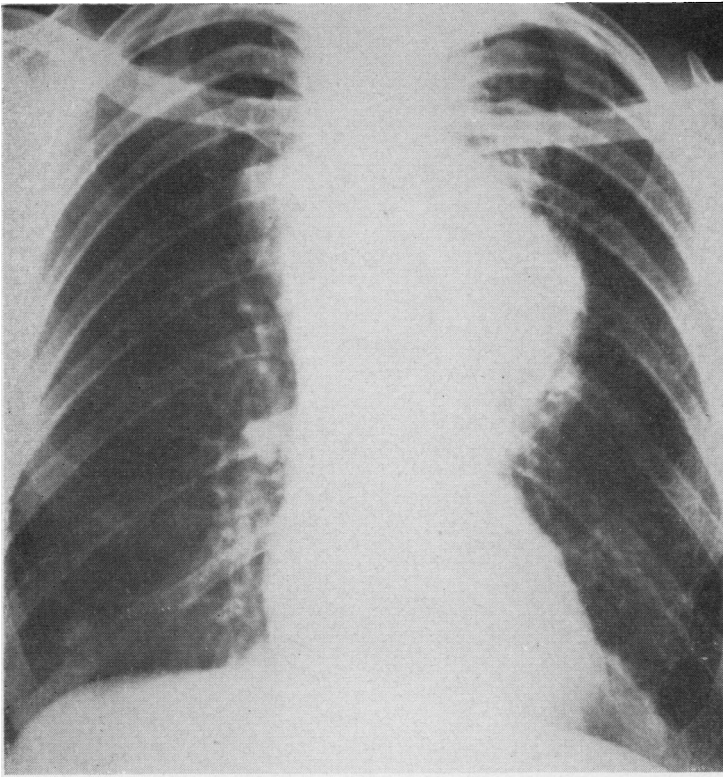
Case 10. Radiograph taken 16 April 1964, before the start of treatment. There is a large mass in the left upper lobe infiltrating the left upper mediastinum with contralateral mediastinal lymph node metastases.*
